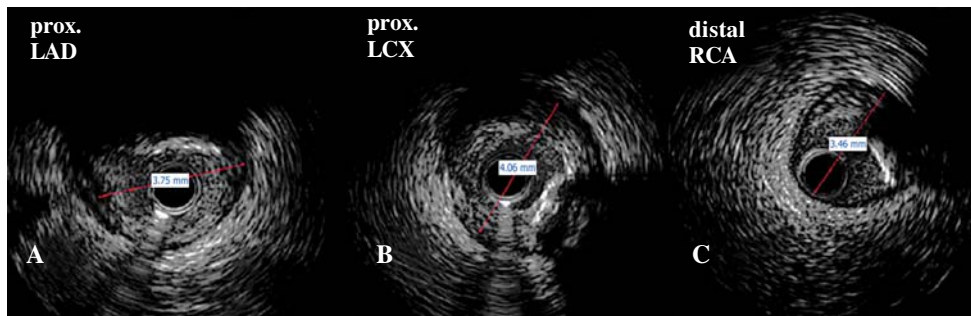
Intravascular ultrasound reveals a large amount of positive arterial remodeling and a reference diameter larger than that indicated by angiography in all three vessels: A – left anterior descending; B – left circumflex; C – right coronary artery.
